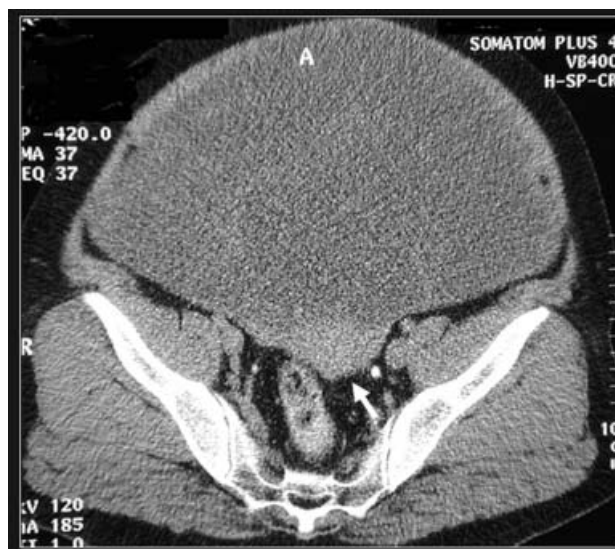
CT image shows a large (35 × 30 × 15 cm), homogeneous, low-density abdominopelvic tumor. The uterine body is visualized posterior to the tumor (white arrow). Even retrospectively, no fat or mucin areas were identified.
